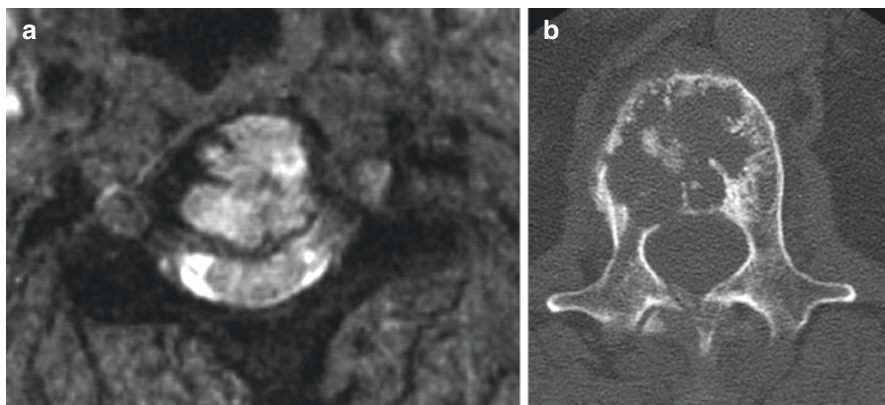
Typical “mini-brain” appearance of a plasmocytoma in a cervical vertebral body on a T2-weighted image (a) and in a thoracic vertebral body on CT (b) (Courtesy image b; J.A. Jacobson, Department of Radiology, University of Michigan, Ann Arbor, USA)
